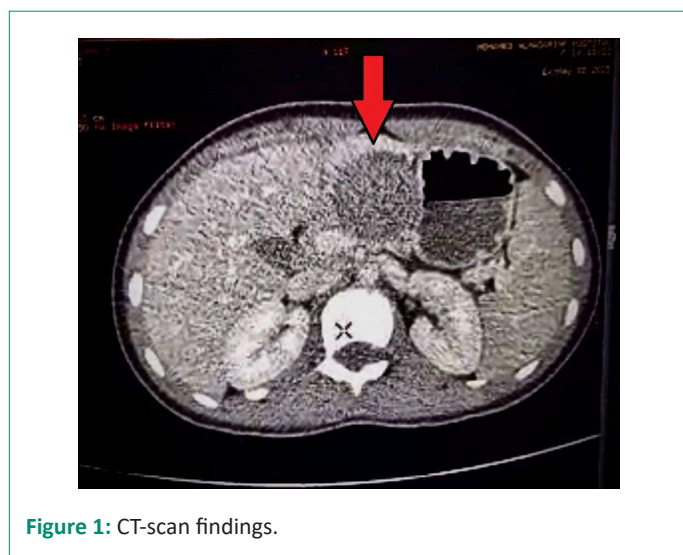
CT-scan findings.
